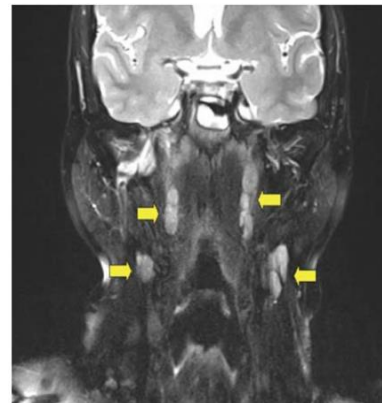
MRI shows bilateral multiple lymph node enlargement (arrows), depicting regional metastases of NPC.
